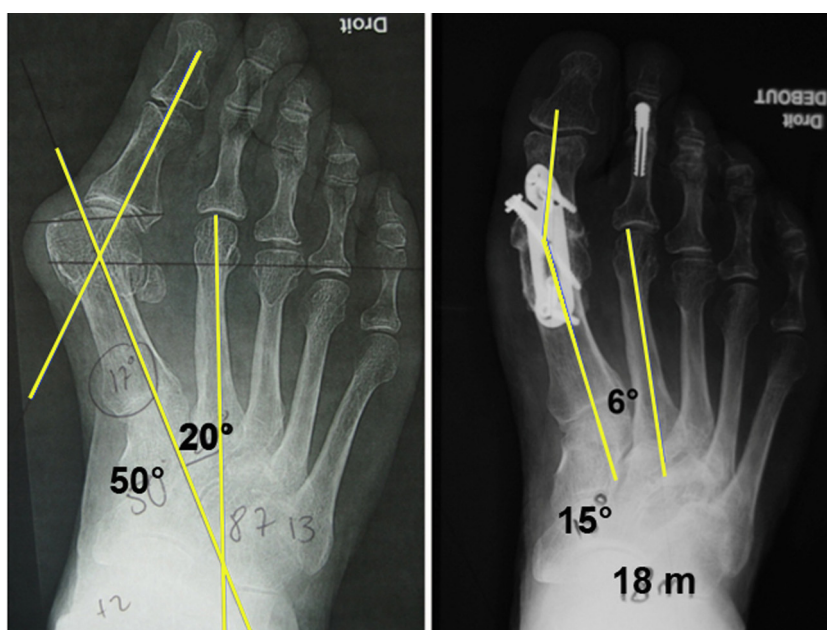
Stage IV hallux valgus in a 78-year-old female patient: preoperative AP dorsal-plantar X-ray with load (left, M1P1 50°, M1M2 20°) and at 18 months postoperative (right, M1P1 15°, M1M2 6°).
